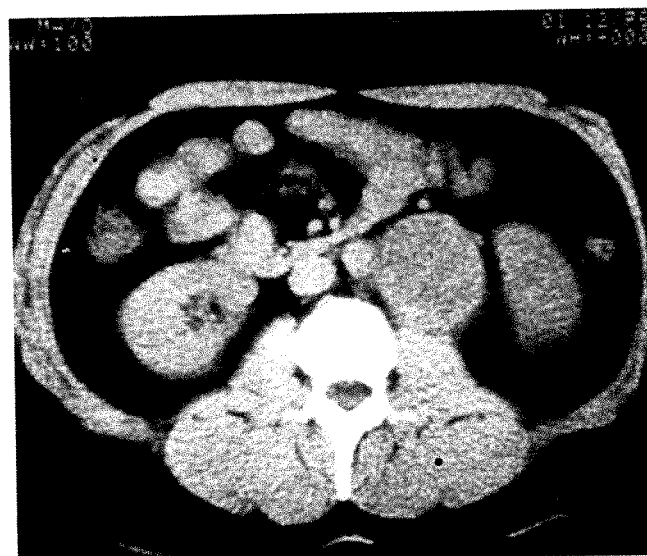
CT scan of 63-year-old man with abdominal pain suggestive of carcinoma of pancreas. Retrograde pancreaticogram and angiogram were negative. Excretory urogram revealed pyelocaliectasis on right. Hydronephrosis of right kidney was associated with small mass of slightly diminished density between kidneys and aorta. Retroperitoneal lymphoma causing obstruction of midright ureter found at operation.
